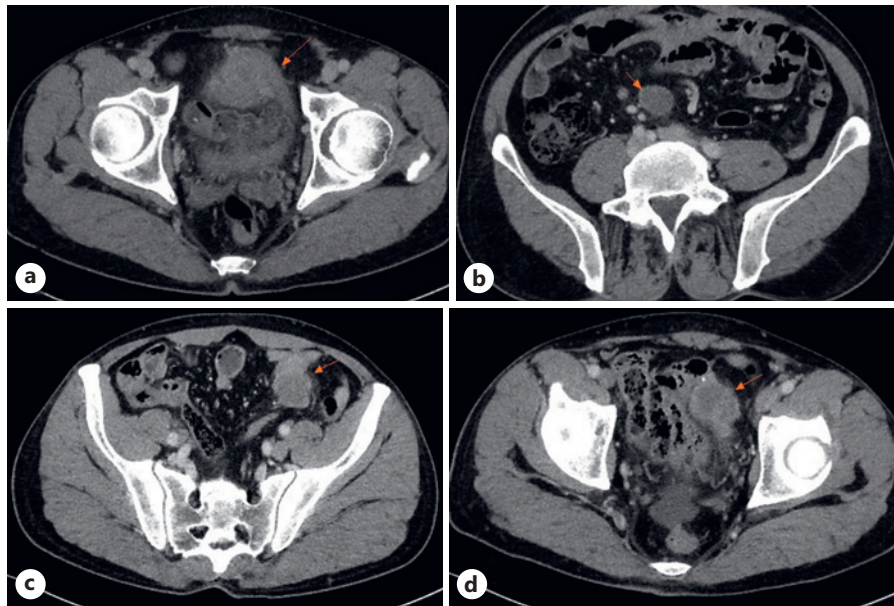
CT findings of the small intestinal metastatic tumor: a Local thickening of the small intestine wall at the pelvic entrance level was about 1.3 cm, and the lesion length was about 5.7 cm b Multiple lymph nodes can be seen at the mesentery root, and the larger ones are about 2.7×2.3 cm in size. c Anastomosis was significantly thickened with mass formation, and the size of the mass was about 3.0×3.2 cm in size. d On the left side of the pelvic cavity, there was another mass above the bladder, about 2.8×3.2 cm in size.
